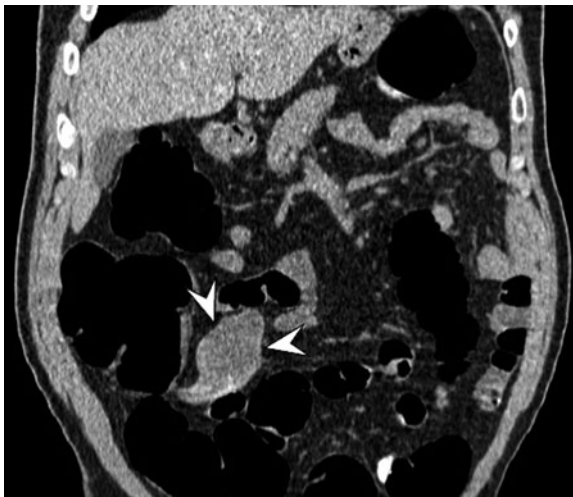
Appendiceal mucinous adenoma detected incidentally at screening CT colonography. Coronal CT image from screening colonography shows bulbous distention of the appendix (*arrowheads*) with low-attenuation material. Note how the base of the appendix tapers to normal caliber, rendering the luminal appearance normal
